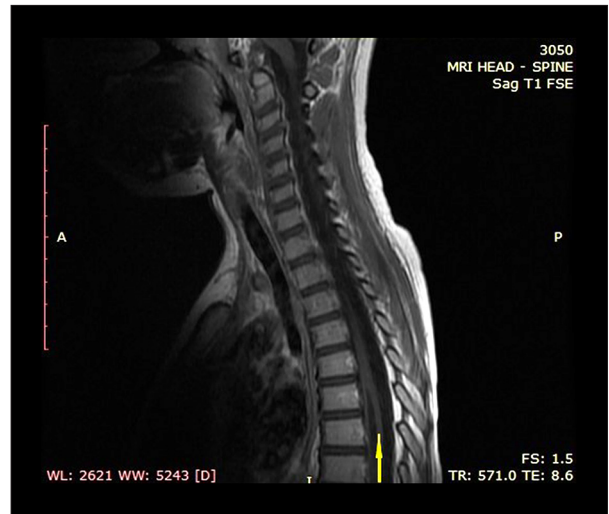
Preoperative sagittal magnetic resonance imaging (MRI), T1 weighted, fast spin echo (FSE) sequence, depicting the lower 1 of 2 syringomyelic cysts located in the cervicothoracic region (arrow).
